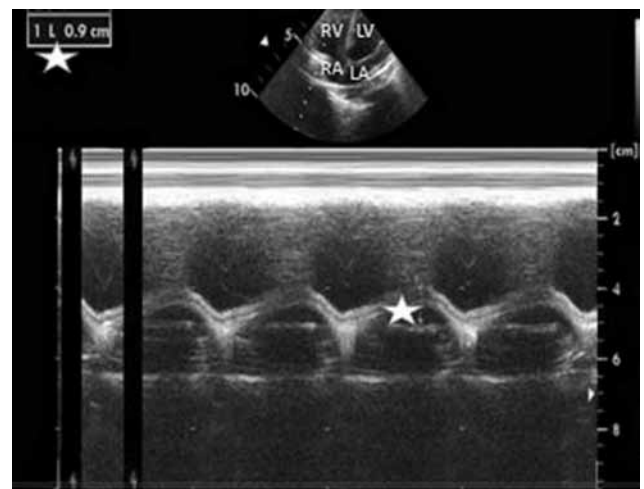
Postoperative transthoracic echocardiographic tricuspid annular plane systolic excursion measurement star sign showed tricuspid annular plane systolic excursion measurement.
